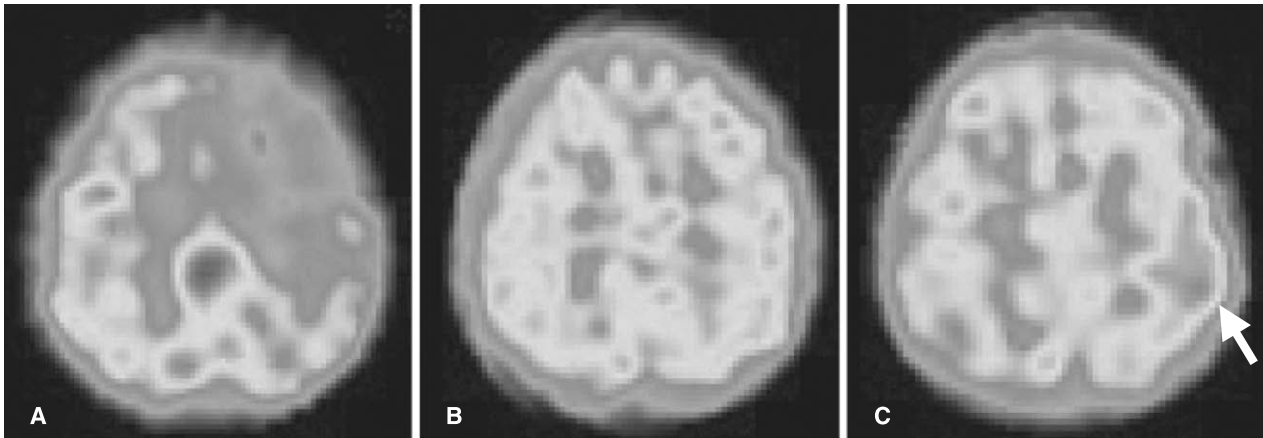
The same patient as in Fig. 1. This 52-year-old woman underwent STA-MCA anastomosis on the left side. Her aphasia was transiently exacerbated during days 2 to 14 after the operation. (A) The preoperative SPECT image shows hypoperfusion in the left frontal lobe. (B) A SPECT image obtained 3 days after the operation demonstrates an increase in CBF in the left frontal lobe; there is no CBF laterality. (C) A SPECT image obtained on postoperative day 10 depicts hyperperfusion in the left fronto-parietal lobe (arrow)
